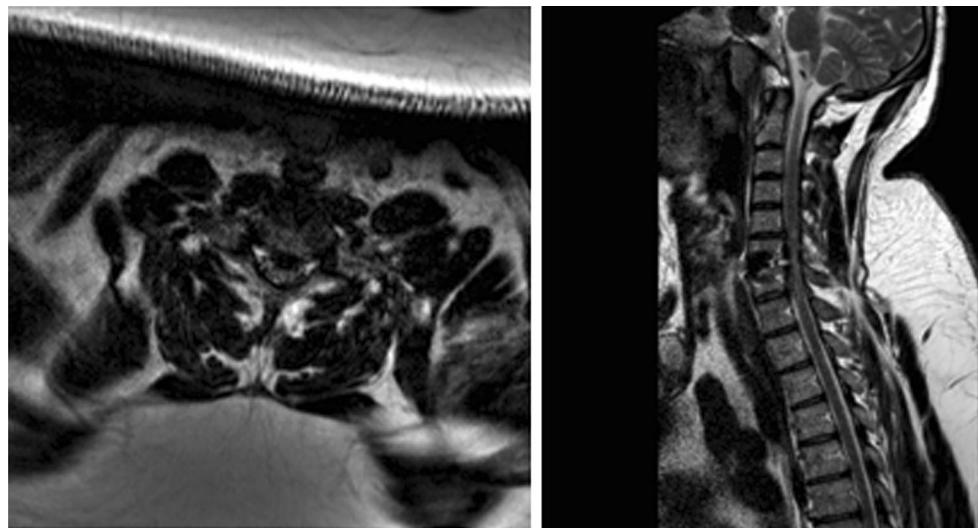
Post-operative MRI (axial and sagittal) showing partial restoration of CSF flow around cord and cord signal changes, but concerns over ongoing compression
